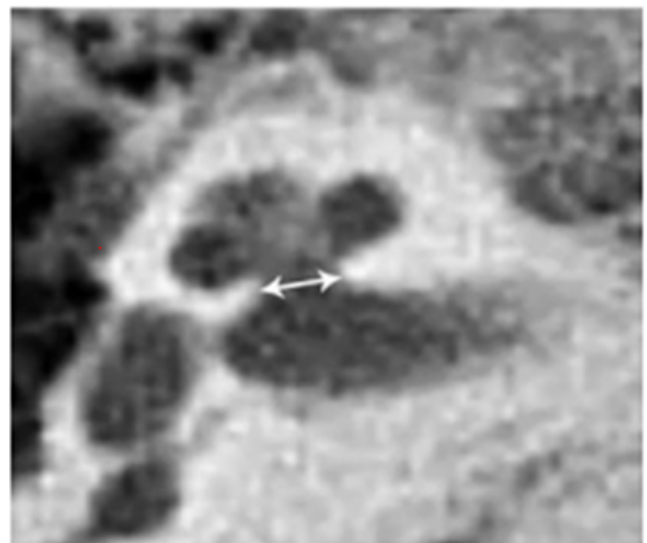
Axial- length resolution CT section showing bony cochlear nerve canal diameter at the mid-modiolar level.
